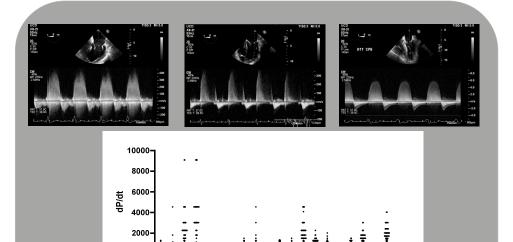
Measurements were performed utilizing two points (100 and 300 cm/s) from the continuous-wave Doppler spectrum of the MR jet.
